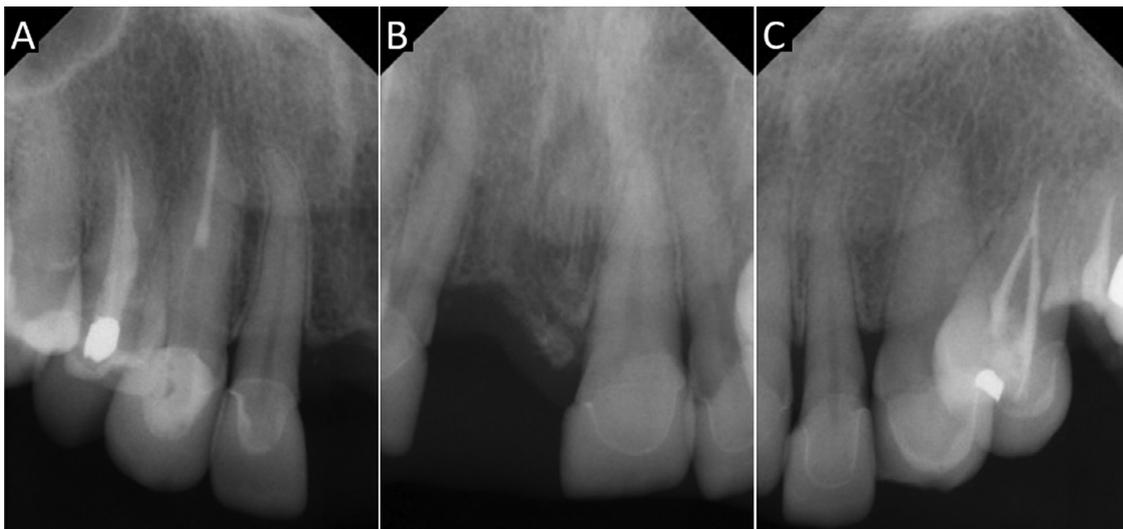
Periapical radiographs showing generalized alveolar bone loss. In the area of the lesion, the alveolar crest appeared higher compared with the alveolar crest level of adjacent maxillary teeth.
